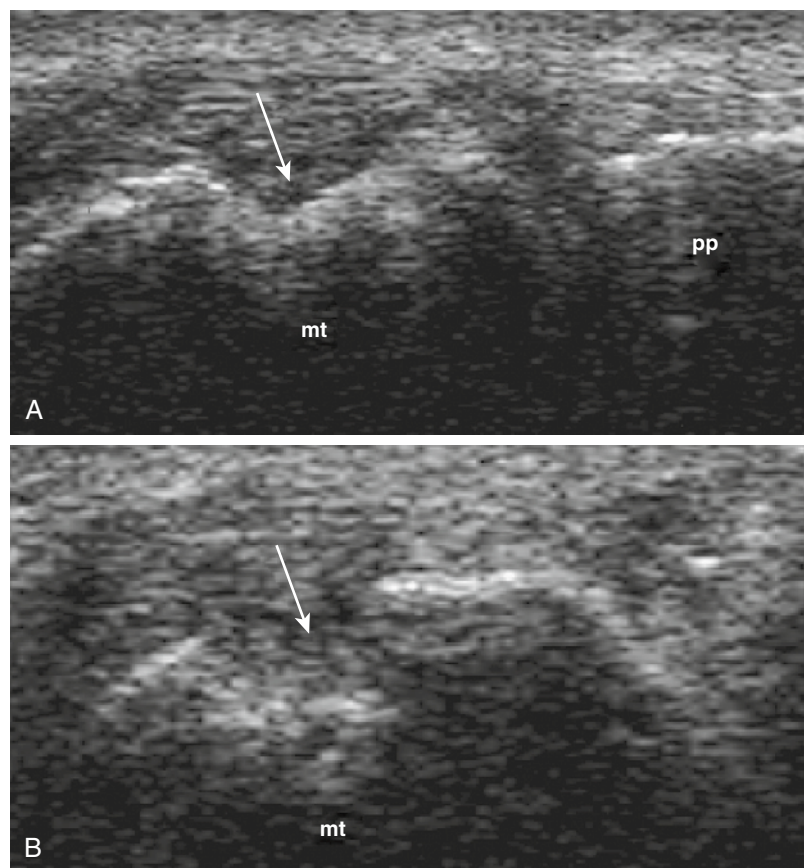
CHRONIC GOUT. Longitudinal (A) and transverse (B) views at the medial aspect of the first metatarsal head show bone erosion (arrows) with no power Doppler signal inside. mt, metatarsal bone; pp, proximal phalanx.
